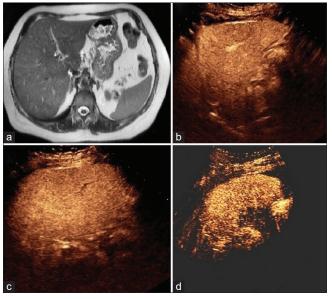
Check after 10 months. (a) MRI no longer shows focal liver and spleen lesions. CEUS confirms the absence of focal hepatic lesions in the left lobe (b) and right lobe (c), and absence of splenic lesions (d). MRI: Magnetic resonance imaging
